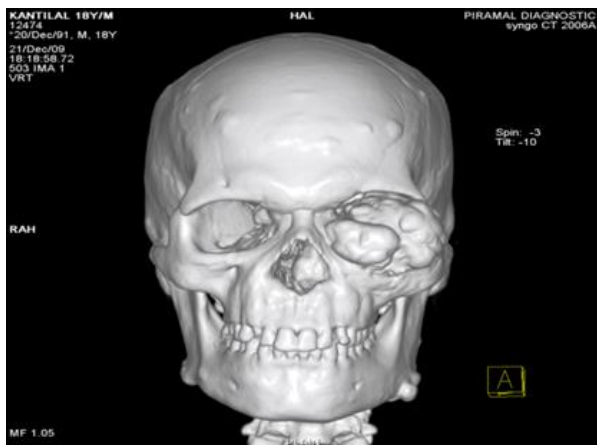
3D CT Face showed large multilobulated mass seen along with left medial, inferior and lateral orbital wall.
